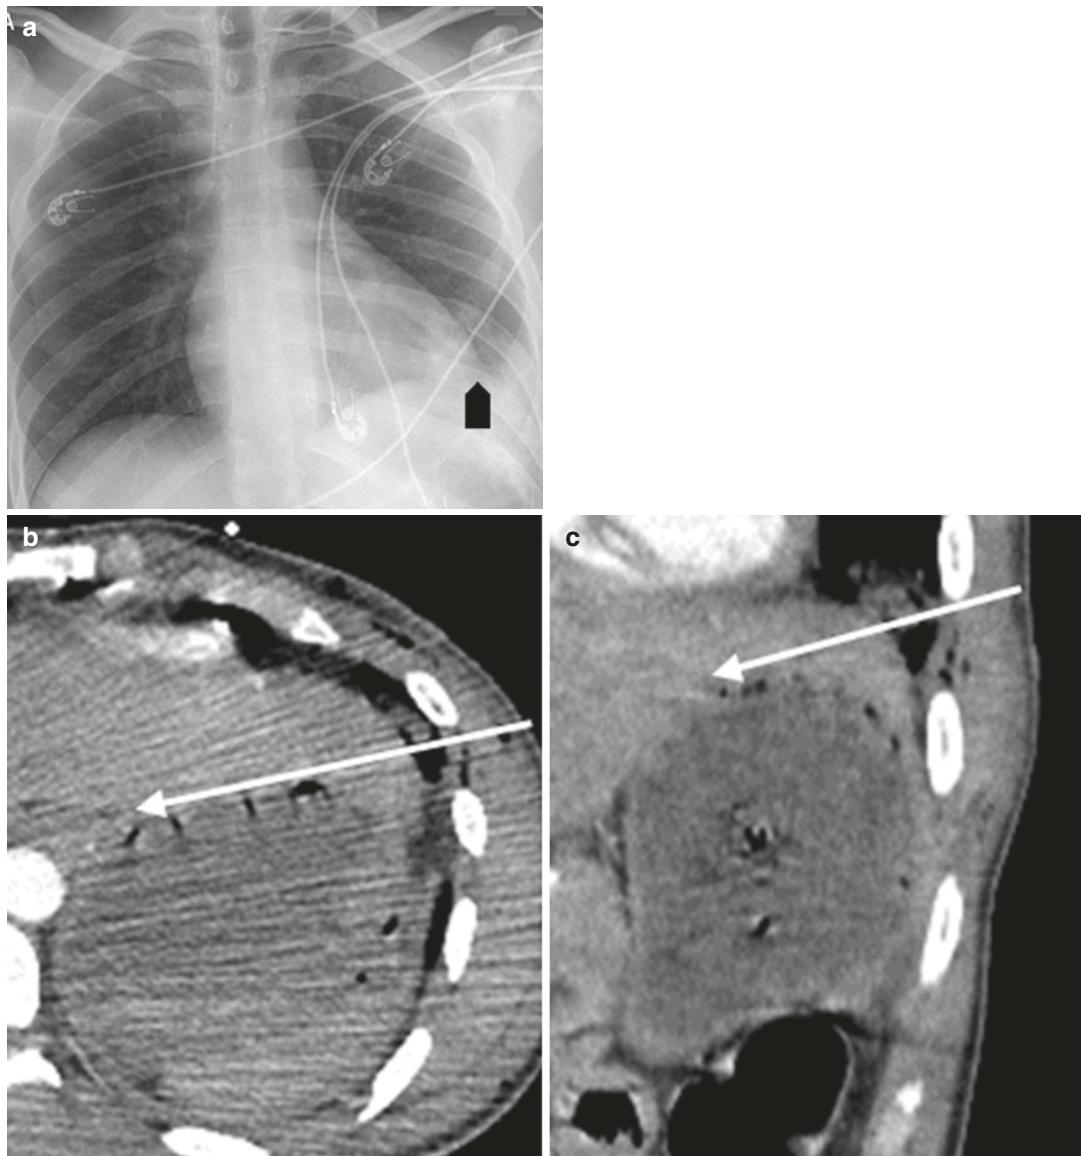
Twenty four-year-old man presenting after multiple gunshot injuries. Chest radiograph (a) shows obscuration of the left hemidiaphragm (arrow). Axial (b)
